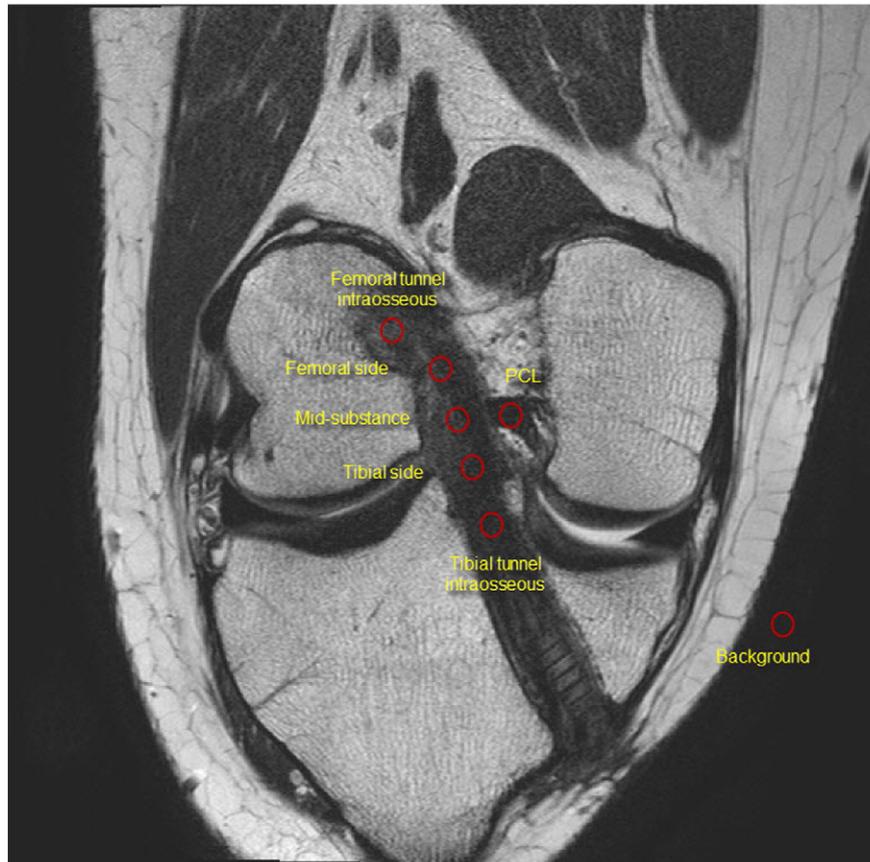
Positions of the regions of interest (ROIs) (diameter of the circle 3.3 mm) of the ACL graft, PCL, and background (one centimeter medial and two centimeters distal to the medial joint line) on the postoperative oblique coronal magnetic resonance image.
